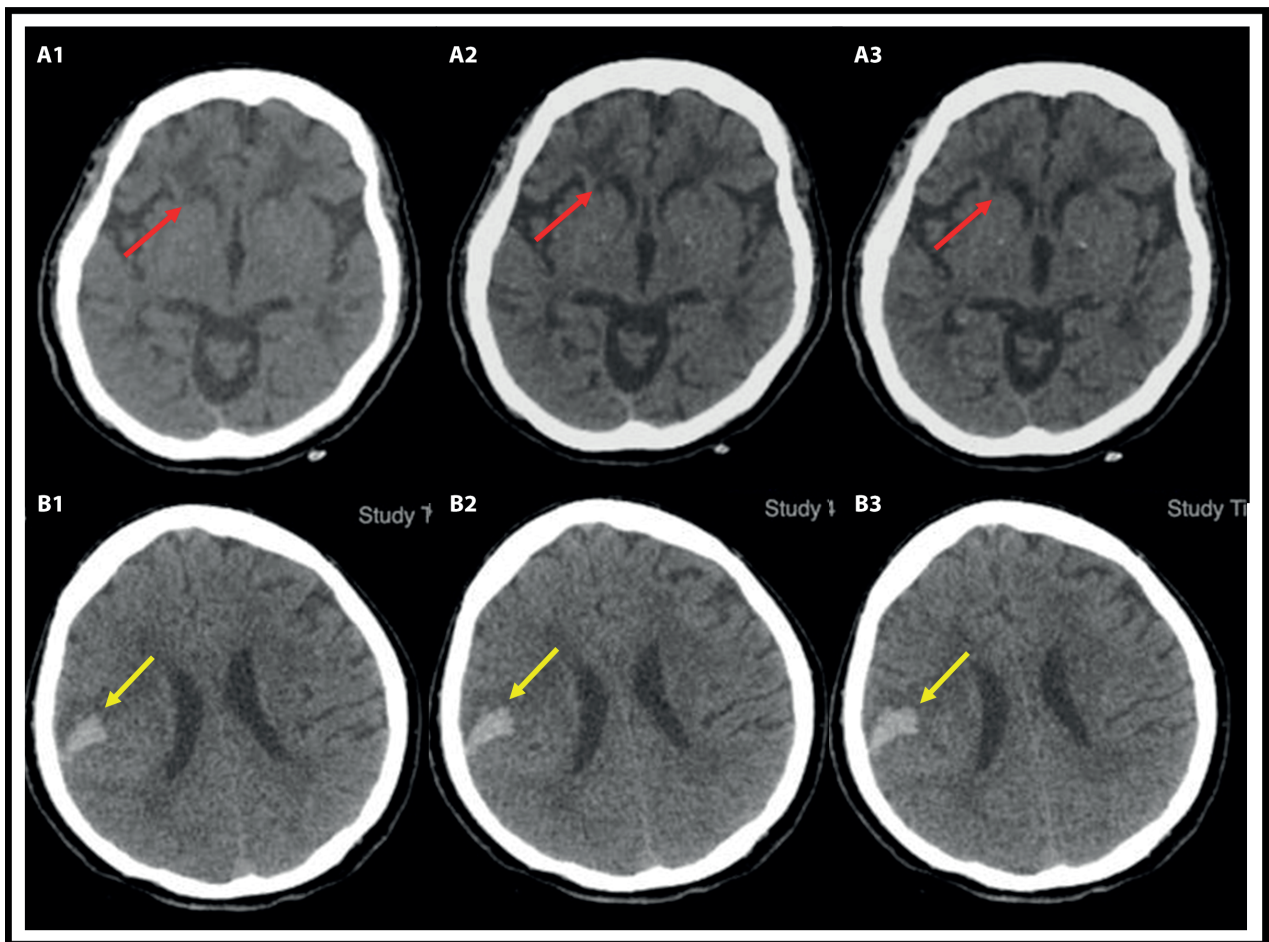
Non-contrast head CT scan of ischemic stroke and hemorrhagic stroke patients. a1, a2, a3). Showing a hypodense lesion with 17 Hounsfield Units (HU), a lacunar infarction in the right lentiform nucleus (indicated by the red arrow) in a patient with ischemic stroke; b1, b2, b3) Showing the presence of hyperdense lesions with 72 HU accompanied by perifocal edema around it with an estimated hemorrhage volume of \pm 2.8 cc in the right parietal lobe in a hemorrhagic stroke patient (indicated by the yellow arrow).
